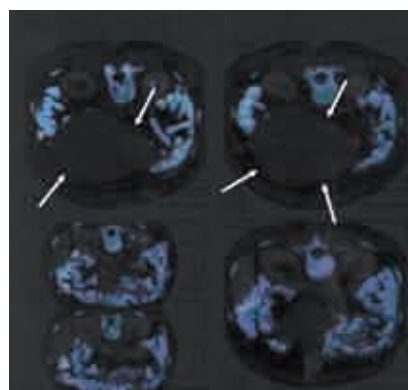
CT scan of the tumor mass in the abdomen.
